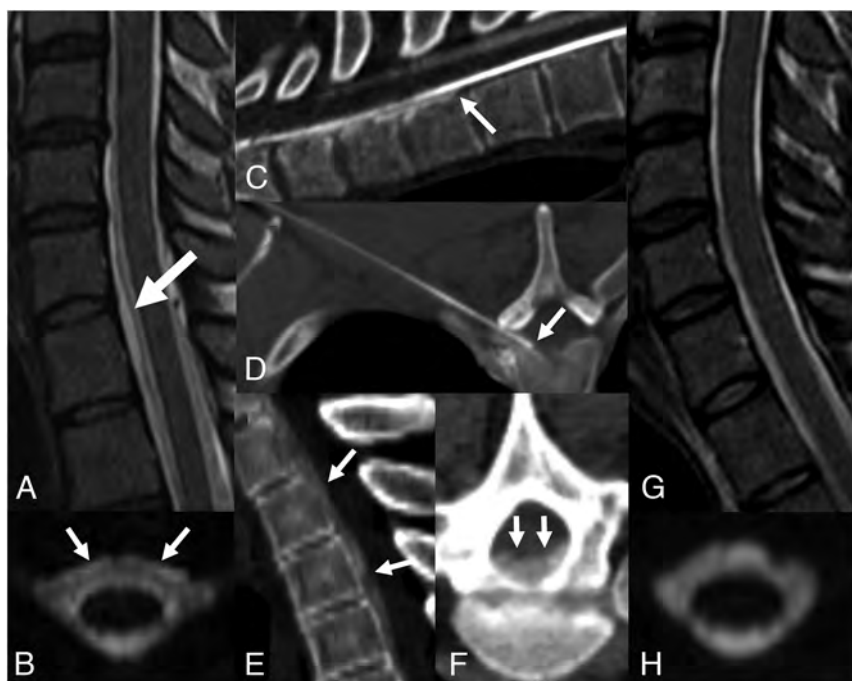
A 35-year-old man with spontaneous intracranial hypotension who underwent 2 prior nontargeted dorsal epidural blood patches. Sagittal (A) and axial (B) T2-weighted MR imaging sequences demonstrate a ventral epidural fluid collection (arrows). C, Prone dynamic CTM detected contrast extravasating from the subarachnoid into the ventral epidural space at T1-2, consistent with a ventral dural defect (arrow). D, Procedural image from a CT-guided epidural blood and fibrin patch using a 15-cm 22-ga spinal needle via a far-lateral transforaminal approach to target the ventral epidural space adjacent to the defect (arrow). Postinjection sagittal (E) and axial (F) images demonstrate spread of injected blood and fibrin glue along the ventral epidural space (arrows). Posttreatment sagittal T2 (G) and axial 3D T2 fat-saturated MR imaging (H) with resolution of the epidural fluid collection.
